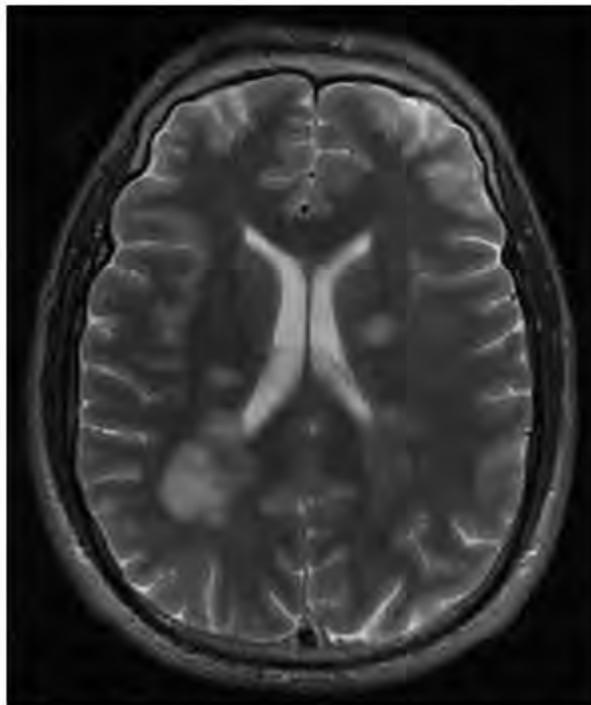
Axial T2 weighted FLAIR sequence demonstrates multiple confluent bright signal intensity foci in the white matter. Adjacent to the posterior aspect of the right lateral ventrical is a larger lobulated, confluent mass-like region of increased signal intensity characteristic of tumefactive MS.
